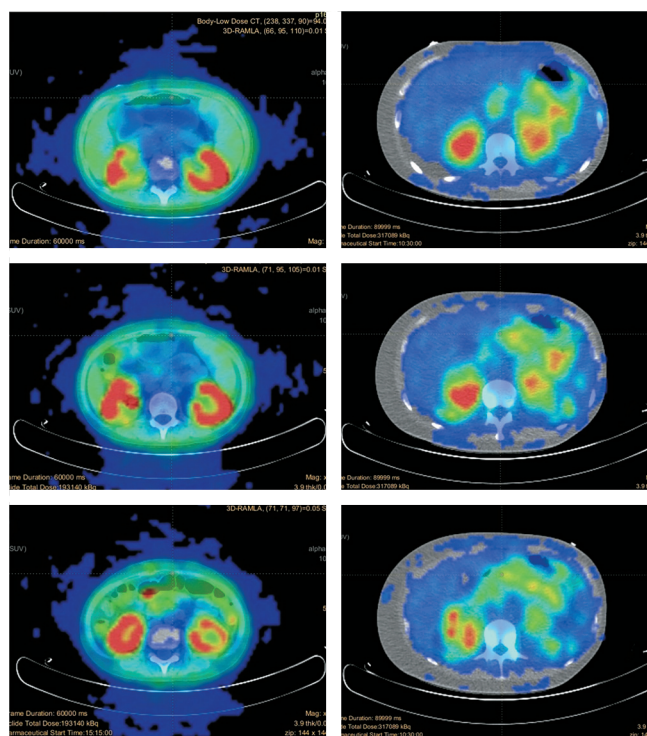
Comparison of PET/CT images of a representative RCC patient and a renal lymphoma patient.
